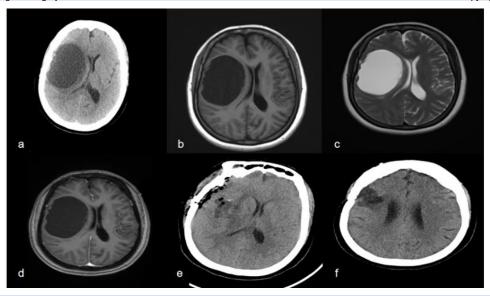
Twenty years of computed tomography (CT) after gamma knife surgery treatment for epilepsy showed a giant cyst in the right frontotemporal lobe.(b) Preoperative magnetic resonance imaging (MRI) showed a cystic lesion in the right frontotemporal lobe appearing isointense on T1-weighted imaging and (c) hyperintense on T2-weighted.(d) No significant enhancement was seen after the enhancement scan.(e) The postoperative CT showed that the hematoma had been emptied.(f) CT scan half year after surgery showed no recurrence of hematoma.
